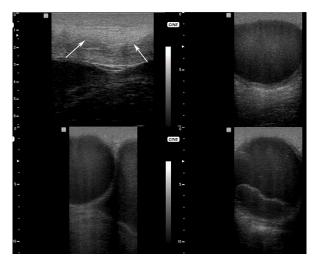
Ultrasonograms of a mucometra due to severe cervical adhesions/stenosis (arrows) in a mare
